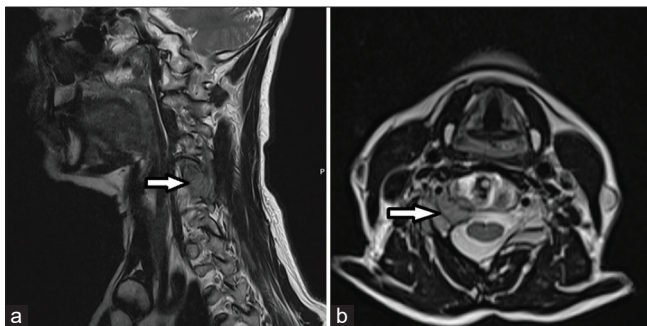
Postoperative sagittal (a) and axial (b) MRI T2-weighted scans a year after surgery revealed tumor recurrence at the previous surgical site. Arrows depict sites of tumor recurrence on both images.
